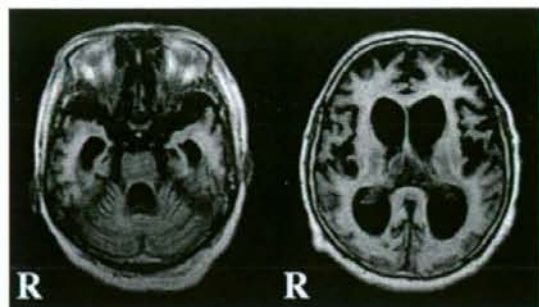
T1-weighted MRIs, obtained 26 months prior to death, show severe cerebral, cerebellar and brainstem atrophy. R, right side.
